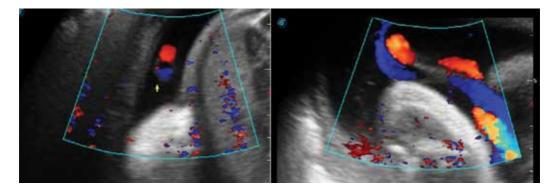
Color Doppler visualization of a free-floating loop of umbilical cord.
